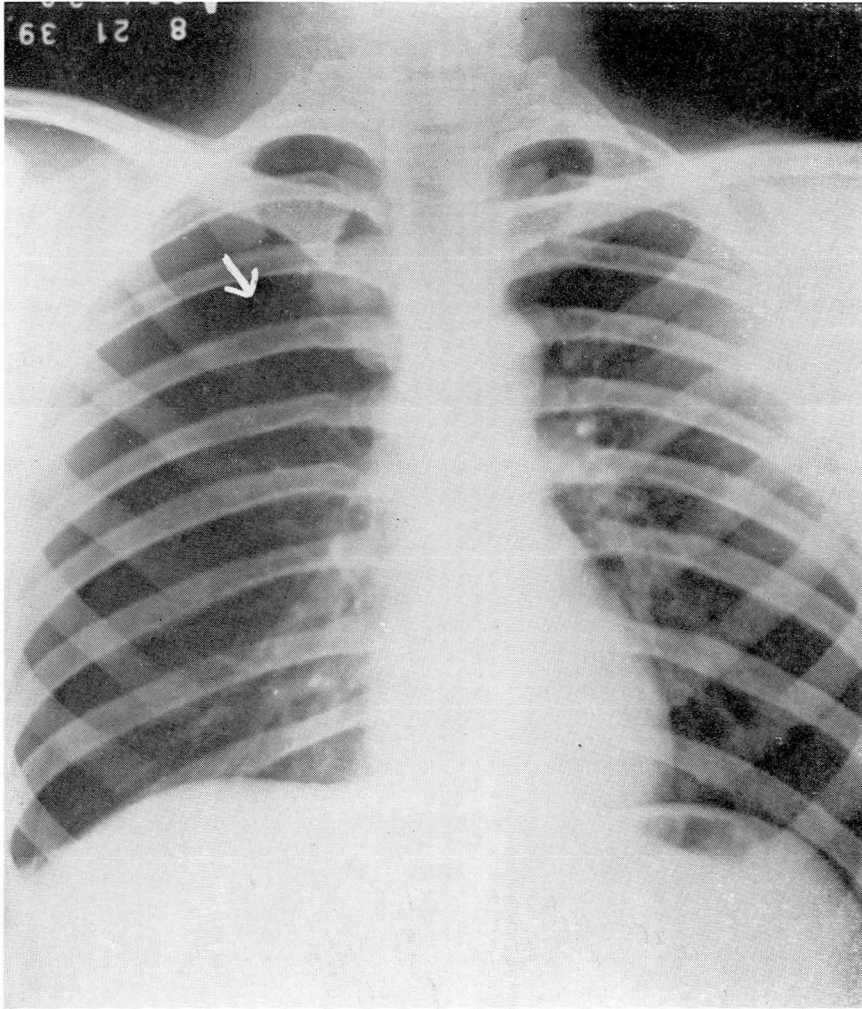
Roentgenogram showing 40 per cent collapse of the right lung. Arrow points to irregularity which might be interpreted as a ruptured pleural bleb.
